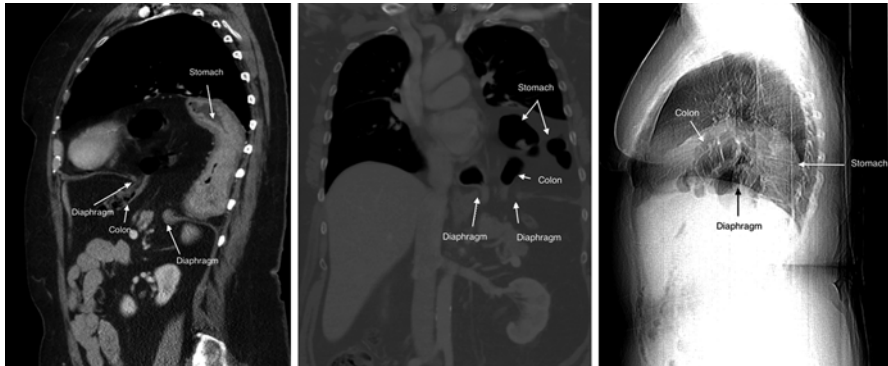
Chest and abdominal CT scan. Type IV hiatal hernia with stomach and colon herniated into the chest
